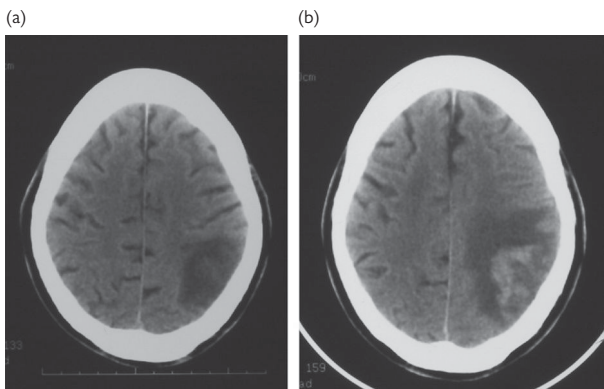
Haemorrhagic transformation on CT. This patient presented with right homonymous hemianopia and dysphasia. (a) A scan on day 1 shows a left parietal infarct; (b) on day 15 she deteriorated with worsening dysphasia. A repeat scan showed haemorrhage within the infarct. © Hugh Markus.
